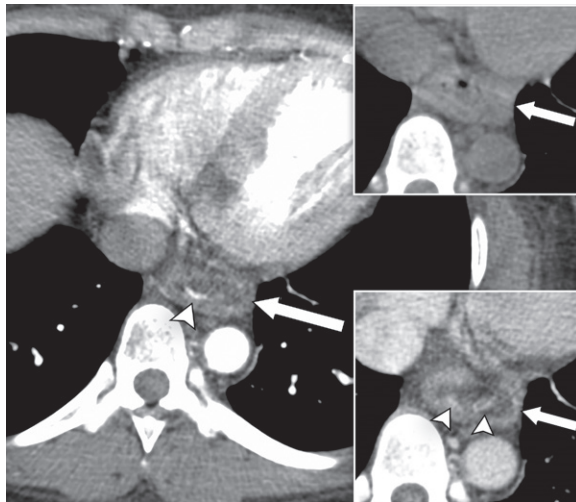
Mallory-Weiss tear with active bleeding in a 30-year-old woman who presented with chest pain, intractable retching, vomiting, hematemesis, and anemia. Axial arterial phase (main image), noncontrast (top inset), and portal venous phase (bottom inset) CTA images show circumferential distal esophageal wall thickening (arrows in all three images), periesophageal stranding and trace fluid, fluid in the esophageal lumen, and a linear focus of contrast extravasation in the posterior esophageal lumen (arrowhead in main image) that changes in size, attenuation, and shape in the portal venous phase (arrowheads, bottom inset), which is consistent with active bleeding.
